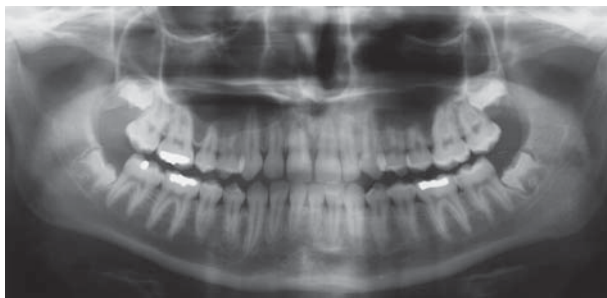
An orthopantomogram of a 45,X female aged 15 years. The tooth roots are shorter in 45,X females than in population control females.
